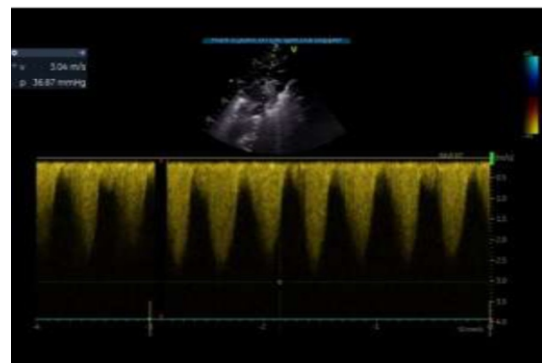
showing Continuous wave Doppler with diastolic tailing and obstruction (pressure difference of 36 mmHg)
